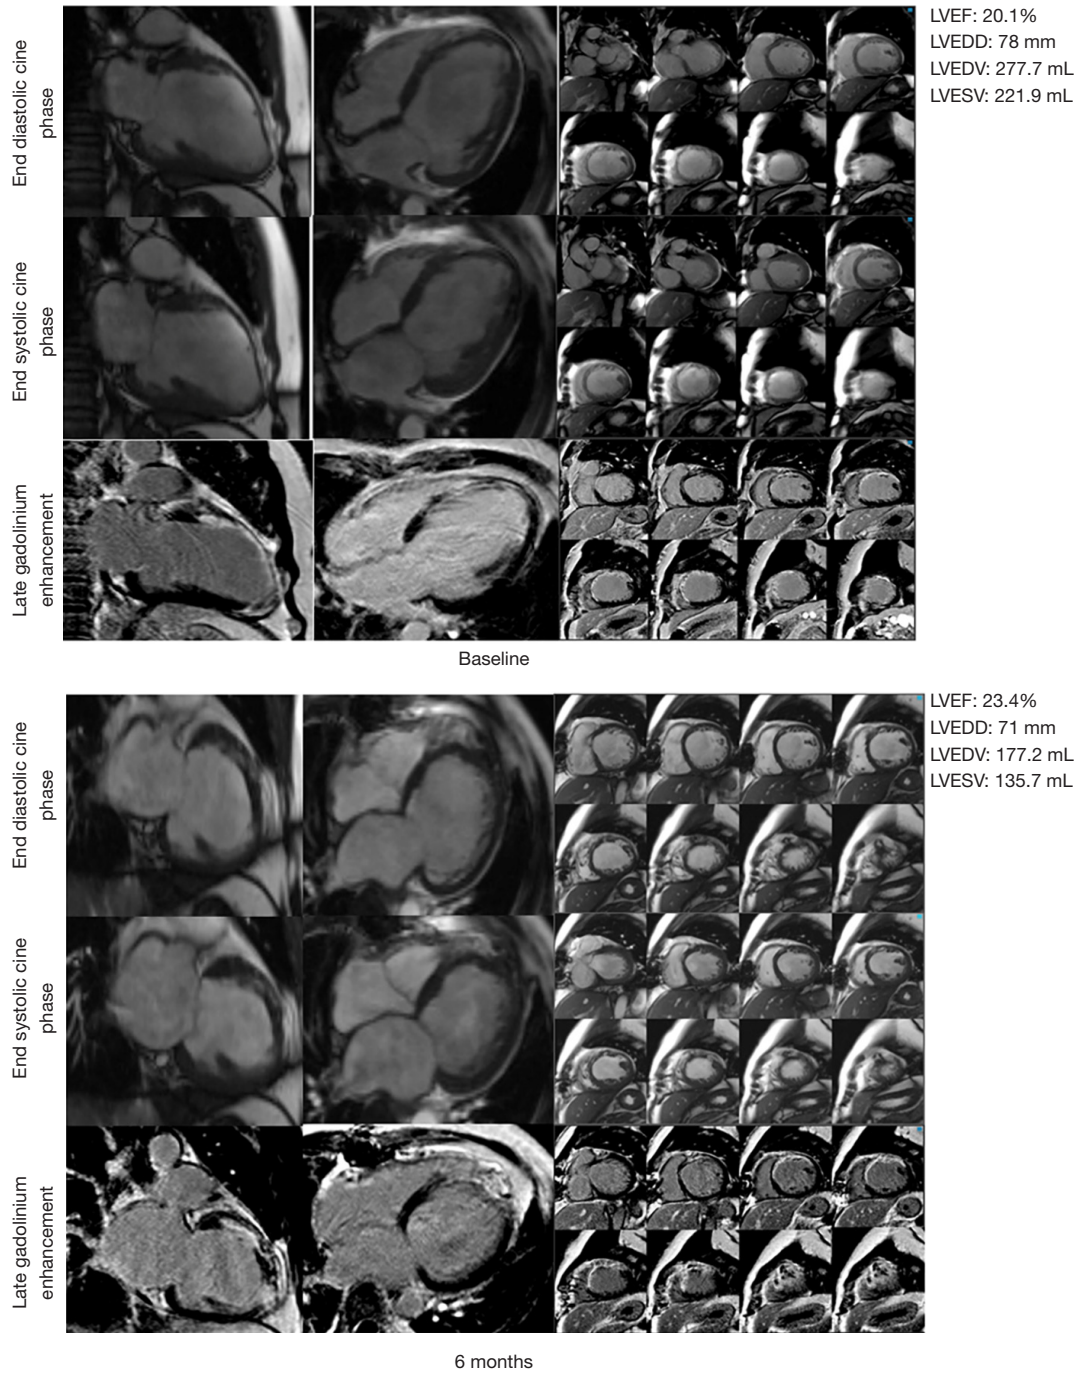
Case 2. The CE-CMR of a patient at baseline and 6 months after CABG+SVR. Example of CE-CMR images before and 6 months after CABG+SVR of a 54-year-old man with a 7-scar segments who survived without CVEs during follow-up. CE-CMR, contrast-enhanced cardiovascular magnetic resonance imaging; I-CABG, isolated coronary artery bypass graft; CVEs, cardiovascular events; LVEDD, left ventricular end-diastolic diameter; LVEDV, left ventricular end-diastolic volume index; LVEF, left ventricular ejection fraction; LVESV, left ventricular end-systolic volume; SVR, surgical ventricular reconstruction.
